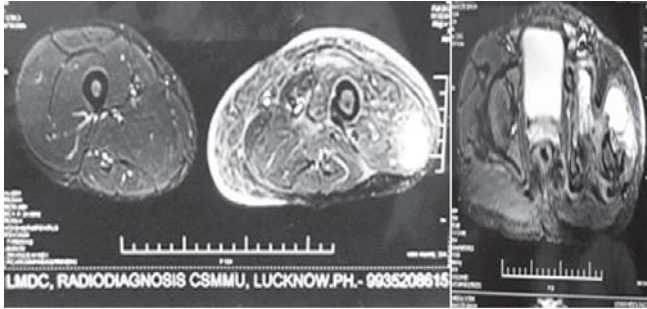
MRI Left Thigh-hypertrophy of Left Thigh and Calf with Signal Intensity Alteration and Heterogeneity of the Muscles and Subcutaneous Fat of Left Thigh
